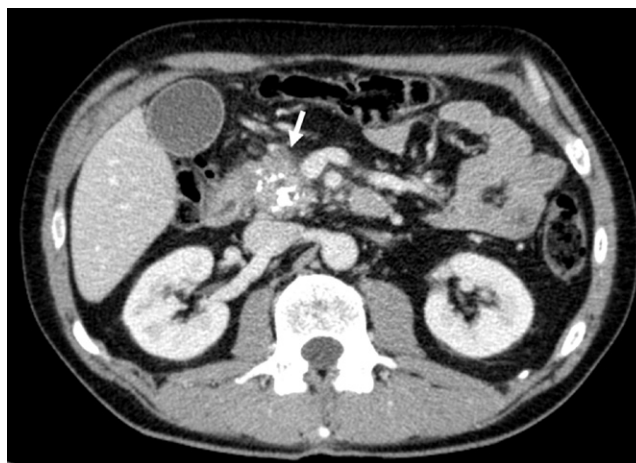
Inflammatory mass of the pancreatic head. Computed tomography: inflammatory mass of the pancreatic head with calcifications (arrow). Source: Courtesy of Thomas Kahn MD, Professor of Radiology, Institute of Radiology, University Hospitals of Leipzig.
